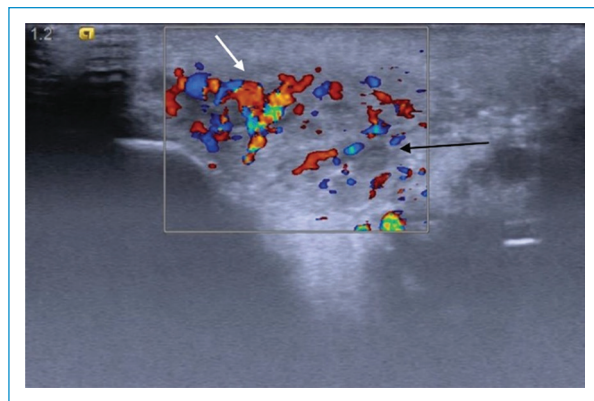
Ultrasound showing an enlarged right parotid gland with heterogeneous texture (black arrow) and increased vascularity (white arrow).
